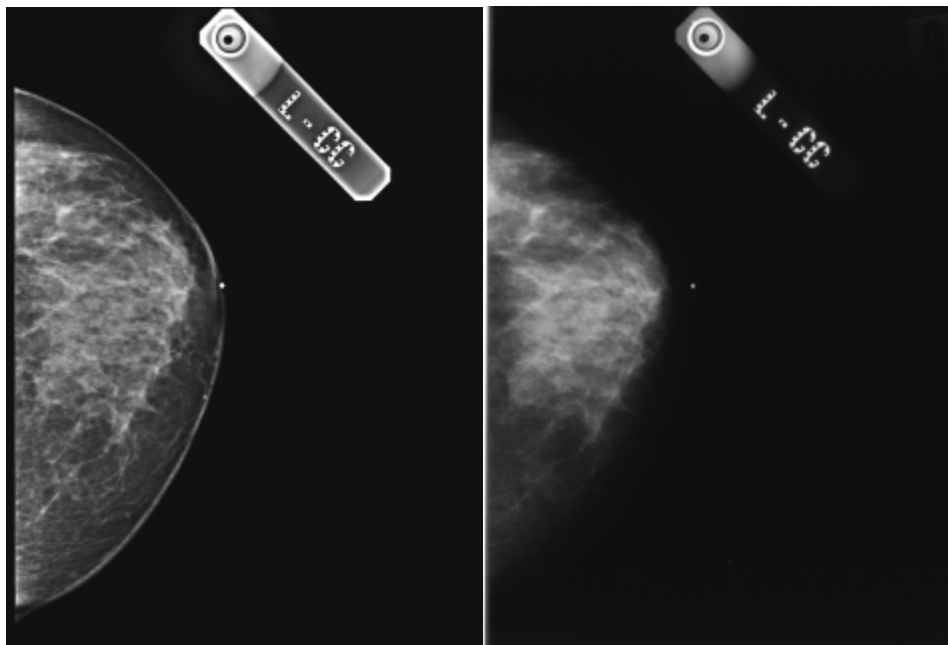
(left) Computed radiography image of the breast, (right) Conventional analog image of the same breast and compression as on the left.
